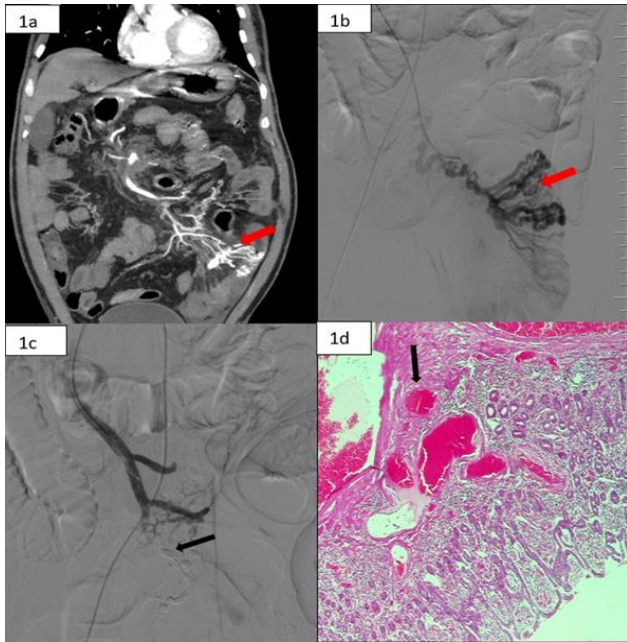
(A-D): CT scan arterial phase coronal view showing AVMs, vascular tufts (arrow); angiographic picture showing AVM (arrow); angiography post embolization partial occlusion of flow into AVM (arrow) and HPE low power showing multiple submucosal vascular channels (arrow).
